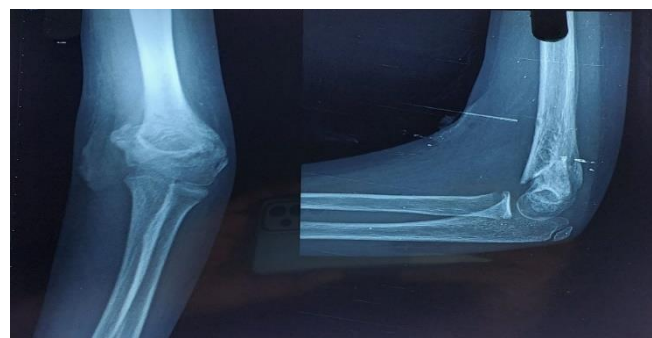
Post-op x-ray images after removal of k wires
